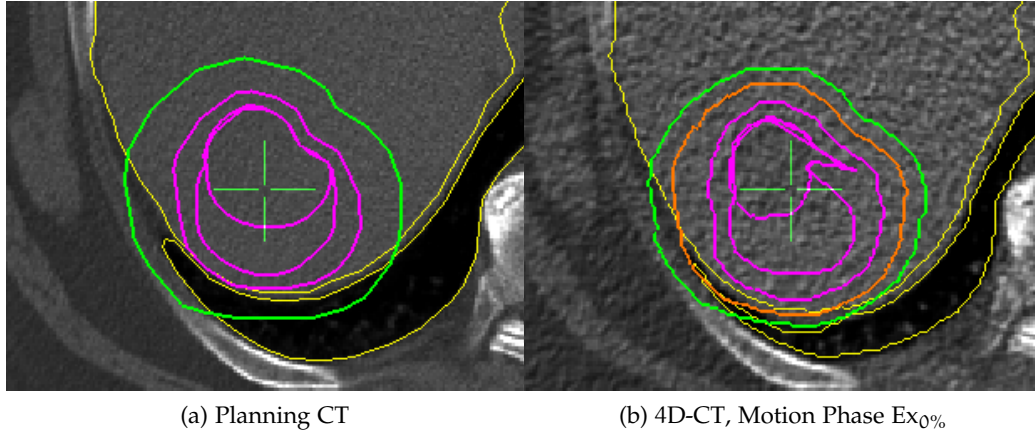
Automated Contour Propagation: Patient volumes are transferred from the planning CT to the reference phase of the 4D-CT. While the PTV (green), CTV (outer purple), liver and lung (both yellow) have been transferred well, the GTV and RF-ablated volume (innermost purple) show artifacts from a malformed vector field. In orange, an ITV has been created from all 4D-CTs.
